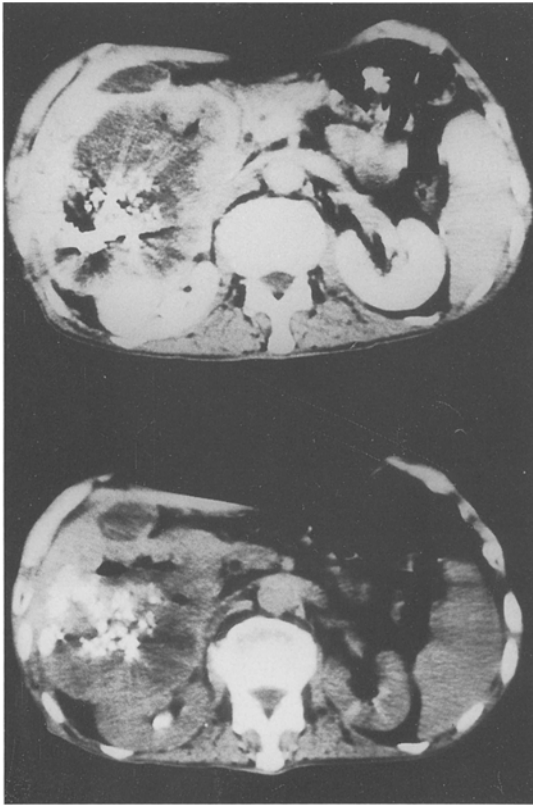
Abdominal computed tomography demonstrates necrosis and shrinkage of a right abdominal tumor after irradiation. The *upper image* was obtained prior irradiation, and the *lower image* was obtained after irradiation
